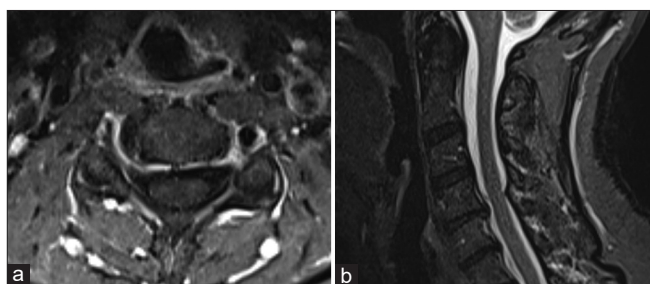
(a) Axial volumetric T1 fat suppressed post contrast magnetic resonance (MR) image and (b) Sagittal short T1 inversion recovery MR image demonstrate no residual venous enhancement or mass effect. The previously visualized flow-related artifact is no longer present.
